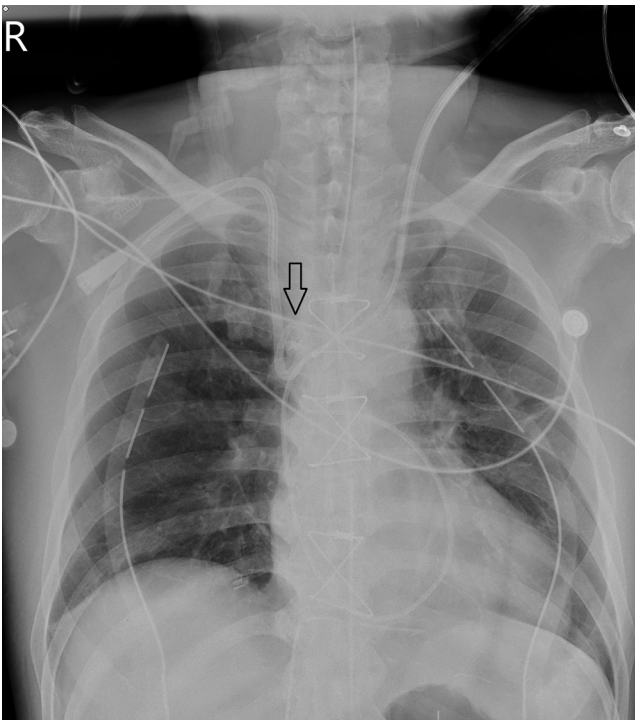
Postoperative chest radiograph showing intraoperative manual repositioning of Perm catheter had resulted in looping of the catheter tip (black arrow).
